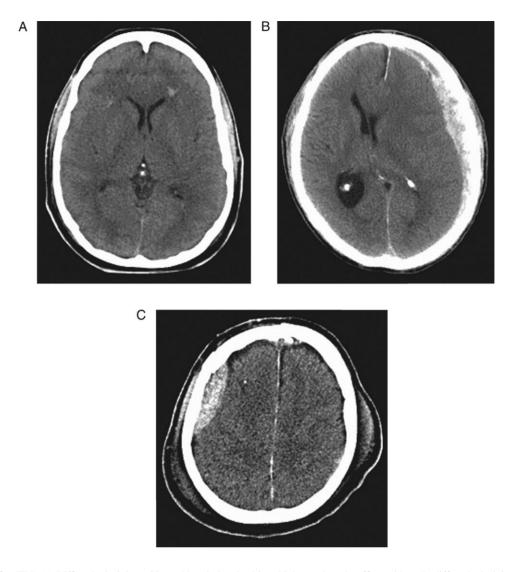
CT scans after TBI. (A) Diffuse brain injury: 32-yr-old male involved in a high-speed road traffic accident. In diffuse brain injury, the CT scan may look grossly normal. Note the small contusion at the tip of the left frontal ventricular horn and diffuse swelling. (B) Subdural haematoma: 39-yr-old male after fall down stairs. Note the large biconcave opacity on the left spreading over the surface of the cortex, compressing the ipsilateral ventricle and causing midline shift. (c) Extradural haematoma: 60-yr-old male after a fall. Note the biconvex opacity on the right compressing the underlying brain parenchyma. Scalp contusions are also demonstrated over the extradural and opposite to the lesion.
